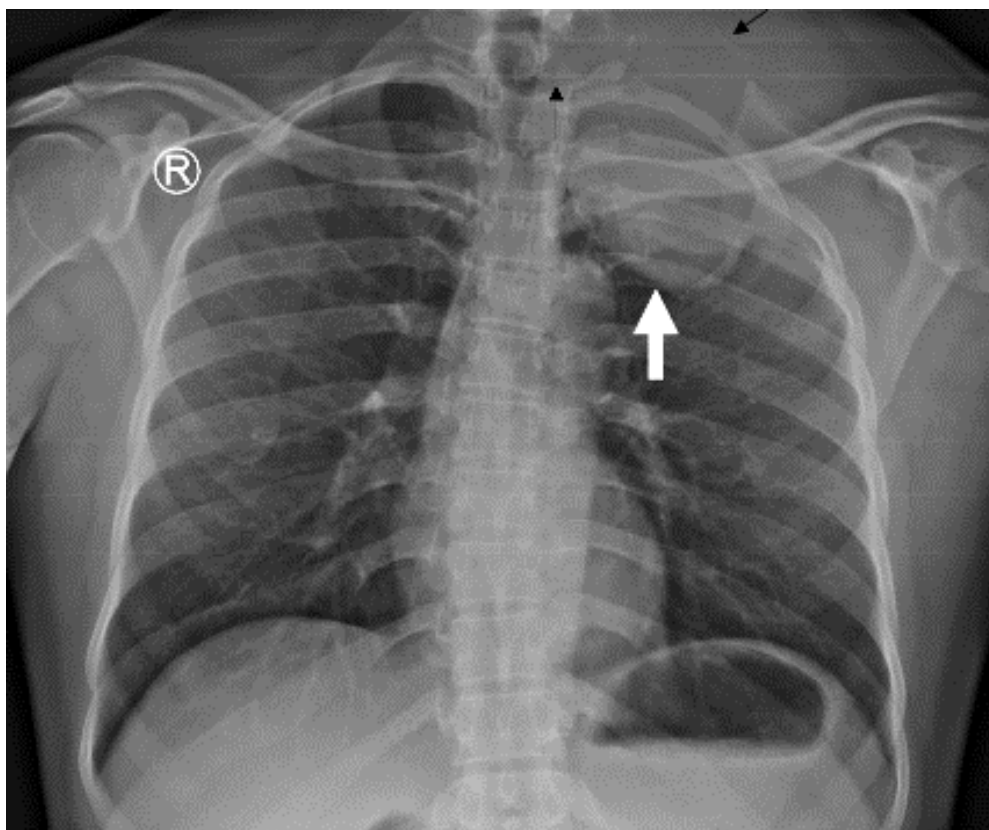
Chest radiograph (Posterior-anterior projection). Opacity of soft tissue density at the left apex with a circumscribed convex lower border (white arrow) and a superior aspect obscured by the soft tissues of the neck (black arrow). There is lysis of the left first rib and the left aspect of T1 vertebral body (black arrowhead)
